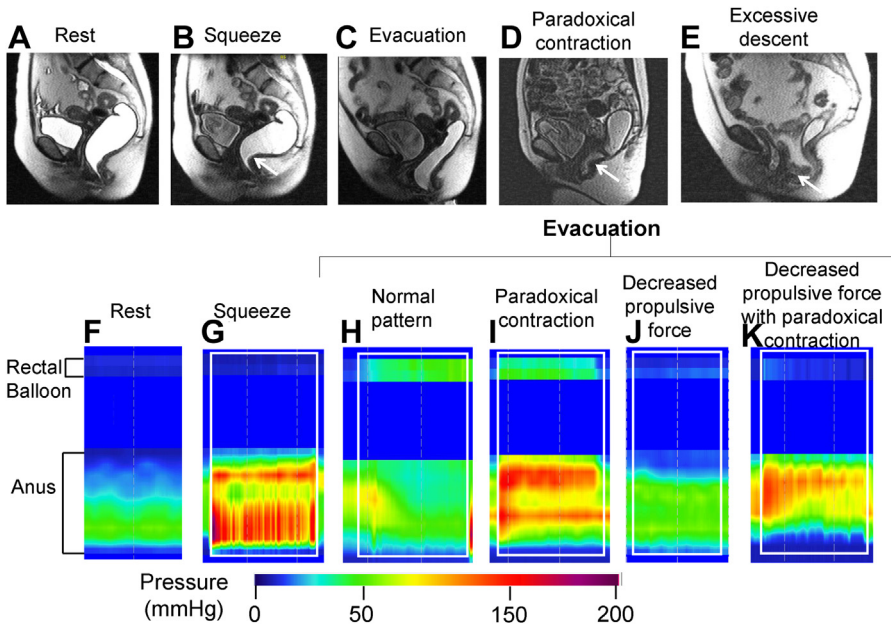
Normal and abnormal anorectal evacuation. Evacuation was recorded by MRI (top row) and HRM (bottom row). Relative to rest (A), MRI shows increased puborectalis indentation during squeeze (B, arrow) and normal relaxation of the puborectalis, perineal descent, opening of the anal canal, and evacuation of ultrasound gel during evacuation (C). In patients with constipation, during evacuation, there is paradoxical contraction of the puborectalis (D, arrow) and exaggerated perineal descent with an enterocele (E, arrow). HRM shows anal pressure at rest (F) and increased anal pressure during squeeze (G) compared with rest (F). The white rectangle demarcates the duration of squeeze (G) and evacuation (H–K). Note the increased rectal pressure with anal relaxation during evacuation in a healthy person (H). By contrast during evacuation in constipated patients, note increased rectal pressure with paradoxical anal contraction (I), no change in rectal pressure versus rest (J), and no change in rectal pressure with paradoxical anal contraction (K). (From Bharucha A, Wald A. Chronic Constipation. *Mayo Clin Proc.* 2019;94(11):2340-2357. <https://doi.org/10.1016/j.mayocp.2019.01.031> with permission.)
